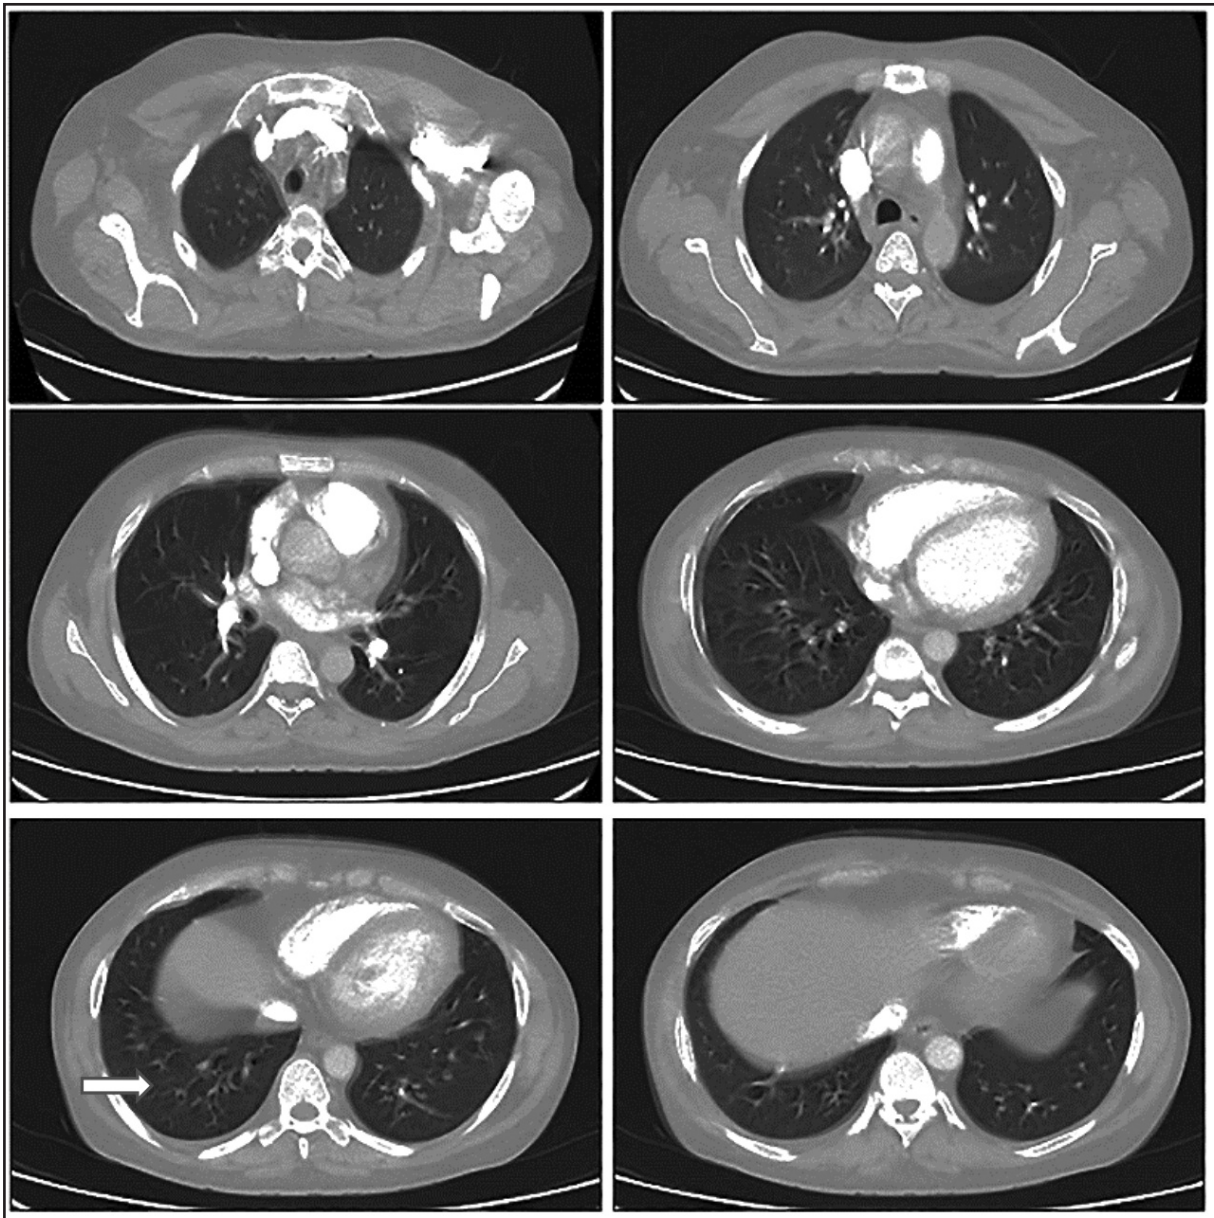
Contrast-enhanced computed tomography of the chest showed ground glass opacities at the right lower zone involving the lung periphery (white arrow).
